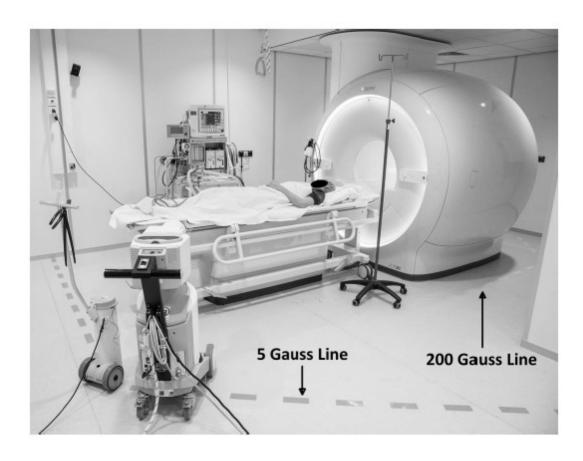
An MRI-HDR BT-integrated suite at the University of Medical Center Utrecht, Utrecht, the Netherlands. Note that MRI-conditional anesthesia cart is available in-room enabling a wide range of treatment procedures. Picture courtesy of Dr Rien Moerland.¹⁹³
